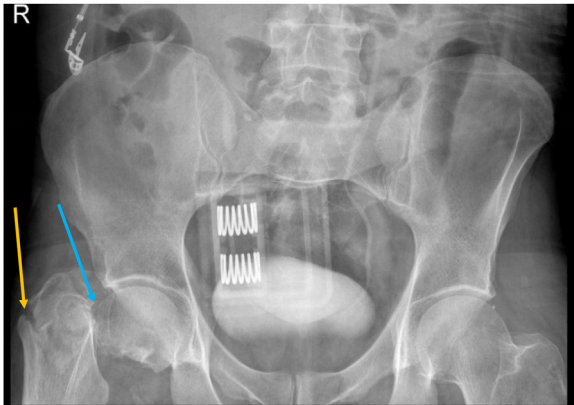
Anteroposterior radiographic view of the patient's pelvis. Blue arrows point to subcapital (intracapsular) fracture. Yellow arrows point to trochanteric (extracapsular) fracture.
